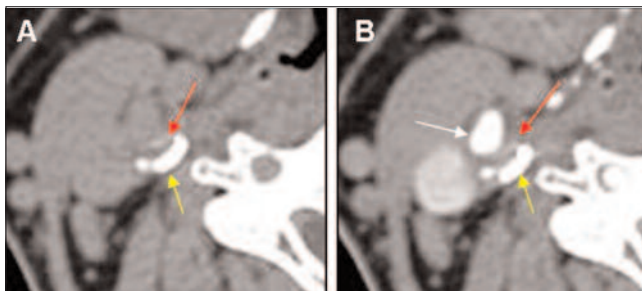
Axial CTA source image in the left carotid bulb.
